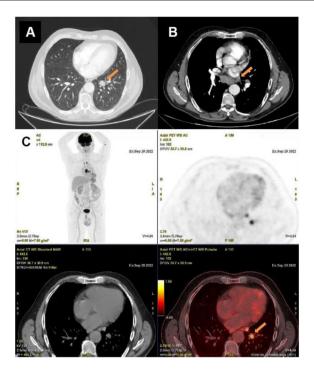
Staging imaging study conducted as part of the diagnostic workup performed to rule out an occult neoplasm. The chest CT scan (A) reveals a pulmonary nodule measuring 21 mm in its largest diameter, located in the left lower lobe, as well as bilateral prevascular (largest measuring 12 mm), infracarinal (largest measuring 21 mm), and hilar adenopathies (largest measuring 17 mm) located on the right side (B). The PET-CT scan (C) revealed hypermetabolism in the pulmonary nodule and the mediastinal adenopathies.
